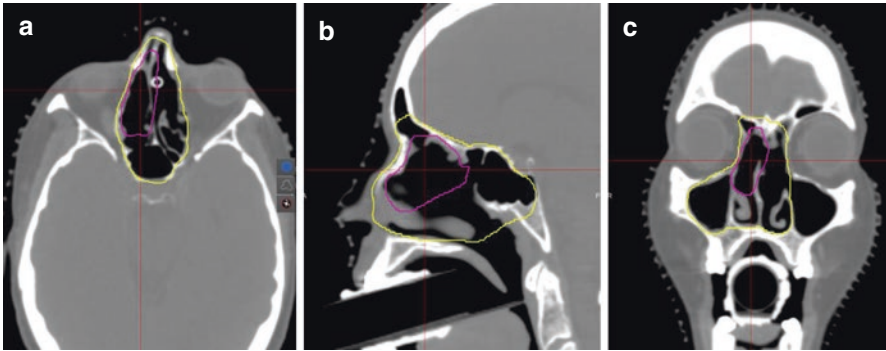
Planning CT of a T3 N0 M0 right naso-ethmoidal sinonasal intestinal-type adenocarcinoma. The pre-opGTV is outlined in the *magenta contour*. The CTV SR (*yellow contour*) includes the entire nasal cavity, the contiguous involved paranasal sinus tissues, and adjacent skull base. Since there was no orbital or intracranial invasion, there is a minimal CTV margin along these boundaries. Since the right middle meatus was involved, there is a generous margin including the entire right maxillary sinus
